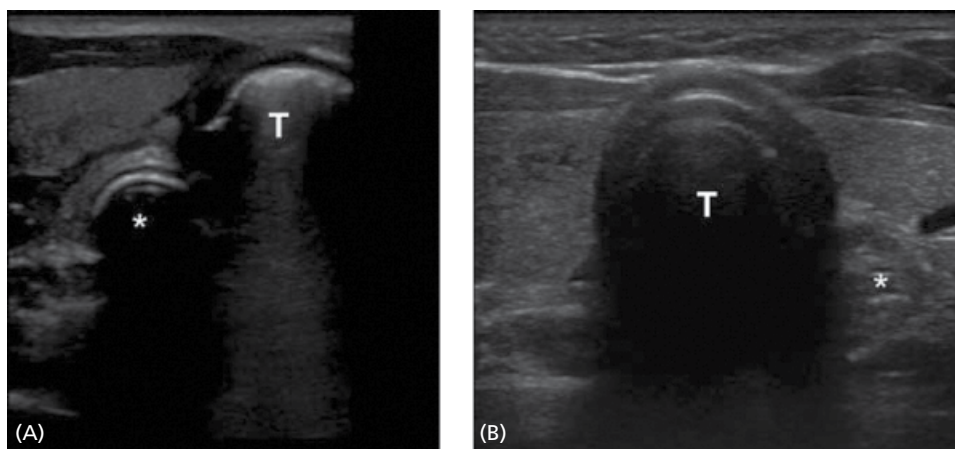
Ultrasound images of endotracheal tube placement. (A) Esophageal intubation. (B) Empty esophagus, tracheal intubation. T indicates trachea and * indicates esophagus. Source: Reproduced from Lin et al [258] with permission of Wolters Kluwer.
